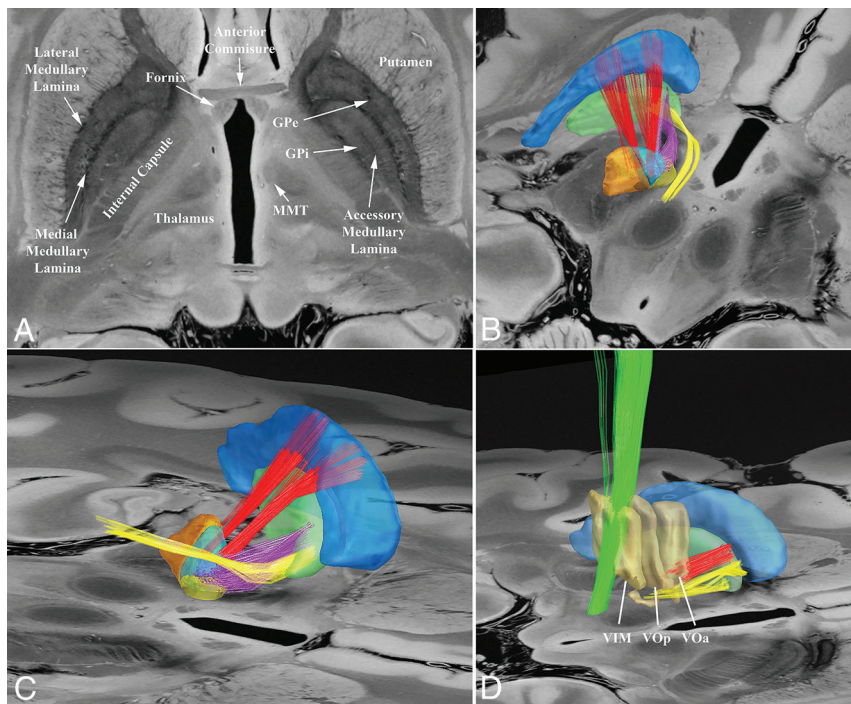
Axial 7T MR imaging (A) showing the anatomy of the pallidum and adjacent structures. Posterior oblique (B) and anterior oblique views (C) highlight the relationship of the AL (yellow fibers) that originates from the anteroventral pole of the globus pallidus internus near the origin of the AS (purple fibers) but courses more dorsal to the AS. The FS is shown as red fibers. Sagittal view (D) shows the components of the thalamic fasciculus: dentatorubrothalamic tract (green), AL (yellow), and FL (red) associated with the VIM, ventralis oralis posterior (VOp), and ventralis oralis anterior (VOa) nuclei, respectively.
